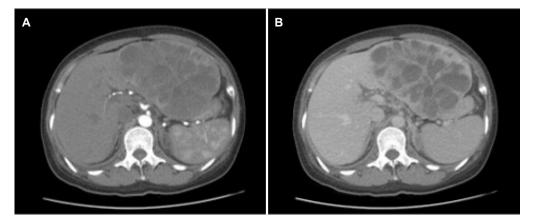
Dynamic liver computed tomography scan. (A) Arterial phase. 14.7×12.7 cm sized non-enhancing multicystic lesion with thick internal septum is found in the left lobe. (B) Delayed phase. Lower density multicystic lesion compared to liver parenchyma is found.
